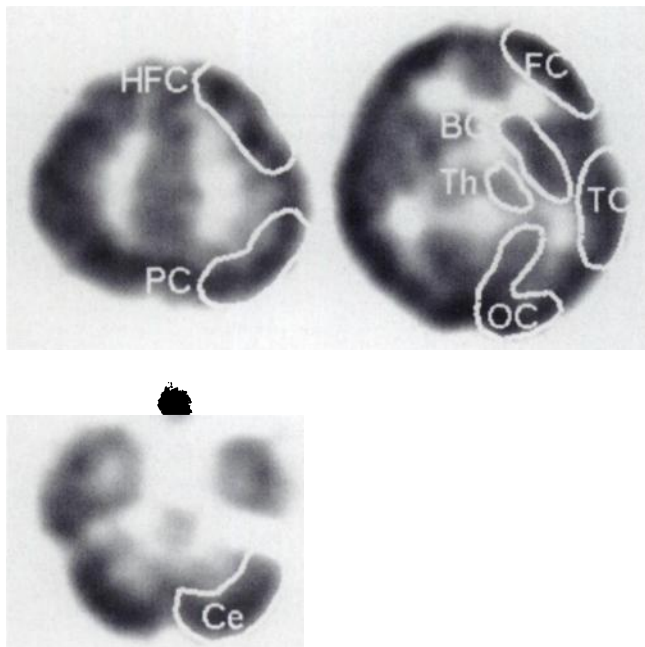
Setting of regions of interest on SPECT images. BG = basal ganglia; Ce = cerebellum; FC = frontal cortex; HFC = high frontal cortex; OC = occipital cortex; PC = parietal cortex; TC = temporal cortex; Th = thalamus.
